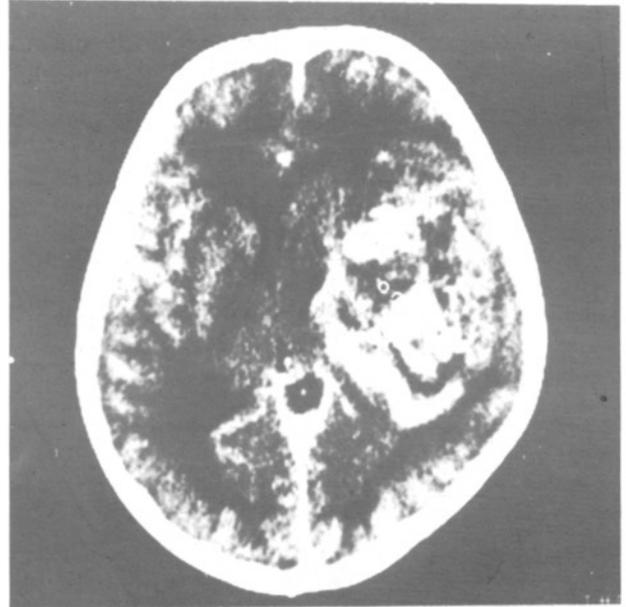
Contrast enhanced CT showing prominent contrast enhancement at the tumour periphery. The tumour shows heterogeneous contrast enhancement and there are some non-enhanced parts at the center.
